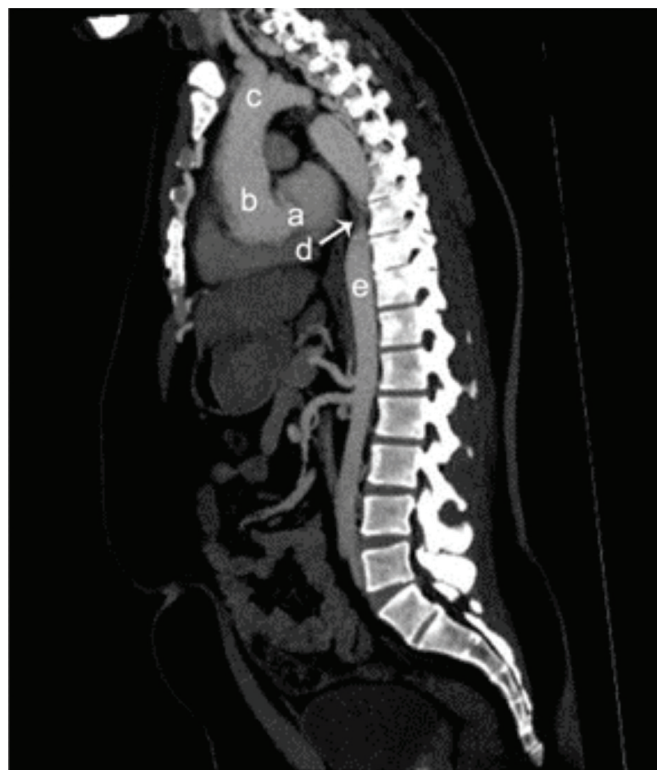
Preoperative sagittal magnetic resonance image of the descending thoracic aorta demonstrating the coarctation (arrow). The sinotubular junction (a), ascending aorta (b), aortic arch (c), coarctation (d), and descending aorta (e) are indicated.
